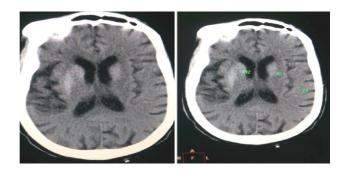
Brain CT scan showing cerebral atrophy and basal ganglia hyperdensities.
